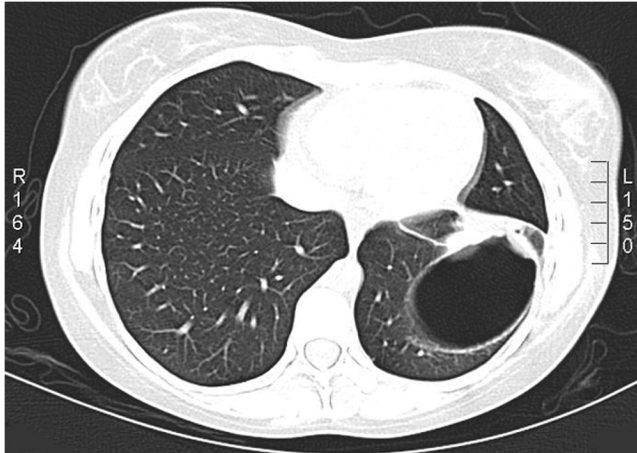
A CT-scan showing a cystic lesion within the left lower lobe.
